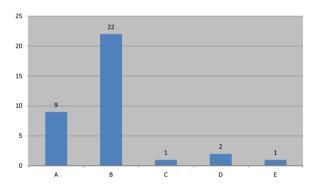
Herniated contents in ultrasound image. A – only small bowel; B – only small or large bowel; C – small and large bowel, liver; D – small and large bowel, stomach; E – small and large bowel, liver, stomach.
